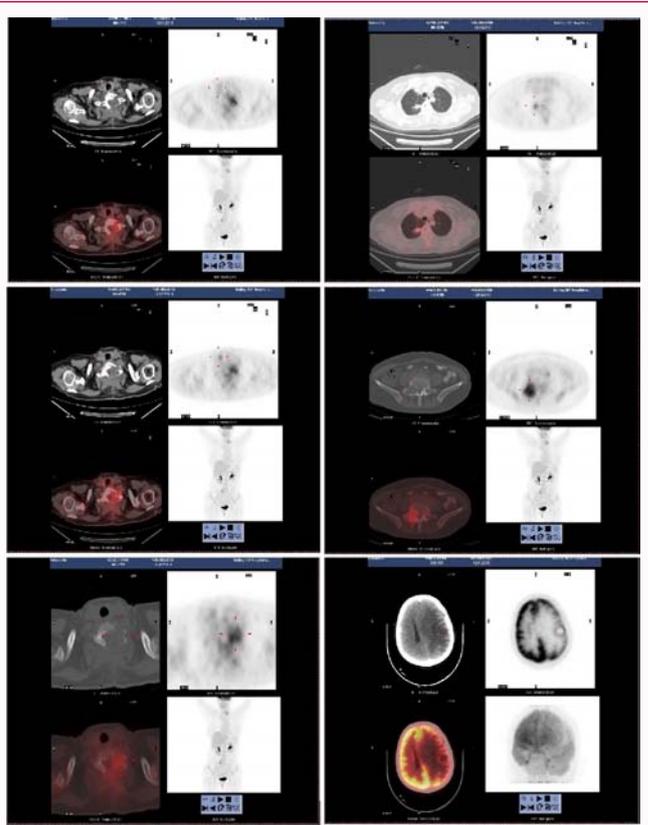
High metabolism of thyroid nodules in the right lobe, multiple metastases in both lungs, multiple bone metastases, and left parietal lobe brain metastases were found on a Fluorodeoxyglucose (FDG)-PET/CT scan.
